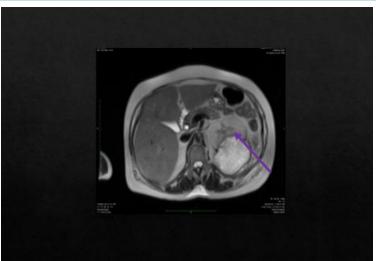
T2W MRI heterogeneously hyperintense lesion in upper pole of left kidney
